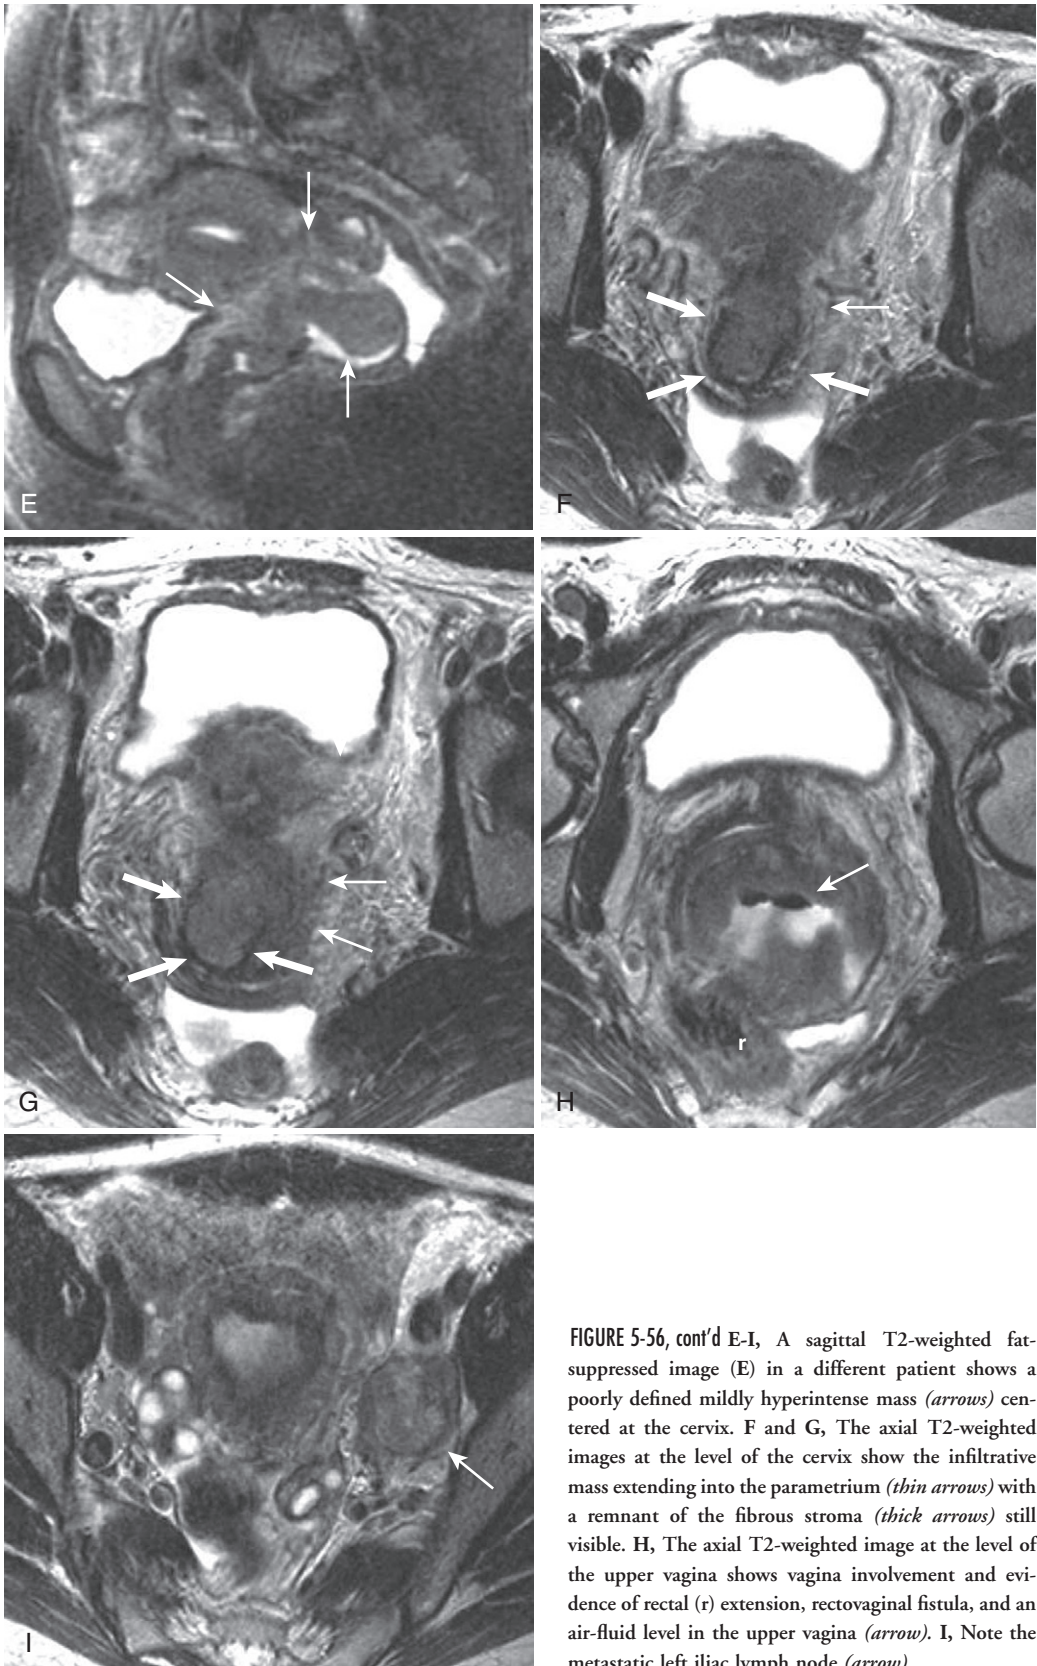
cont'd E-I, A sagittal T2-weighted fat-suppressed image (E) in a different patient shows a poorly defined mildly hyperintense mass (*arrows*) centered at the cervix. F and G, The axial T2-weighted images at the level of the cervix show the infiltrative mass extending into the parametrium (*thin arrows*) with a remnant of the fibrous stroma (*thick arrows*) still visible. H, The axial T2-weighted image at the level of the upper vagina shows vagina involvement and evidence of rectal (r) extension, rectovaginal fistula, and an air-fluid level in the upper vagina (*arrow*). I, Note the metastatic left iliac lymph node (*arrow*).
